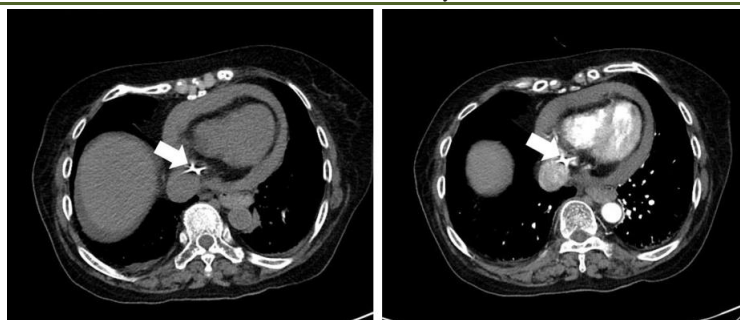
Computed tomography. Hemopericardium and bone cement emboli (arrow)
